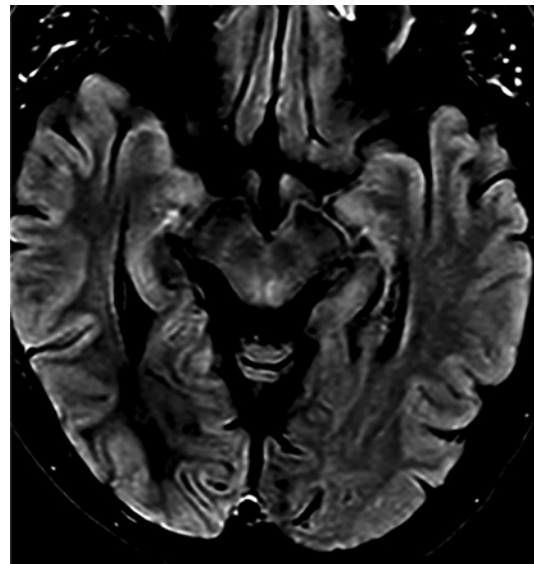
Right occipital gyriform enhancement with FLAIR hyperintense cortical swelling.
